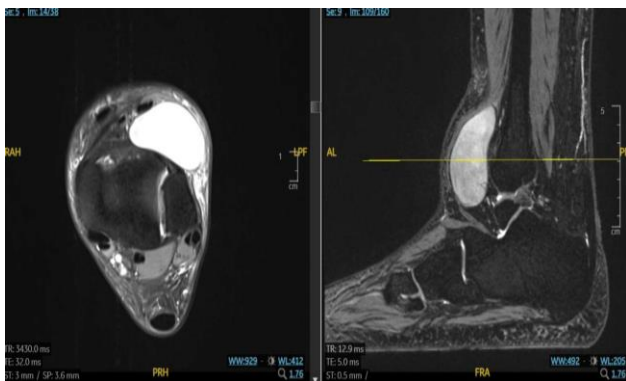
MRI showed well-defined lesions seen anterior to the tibiotalar joint.
